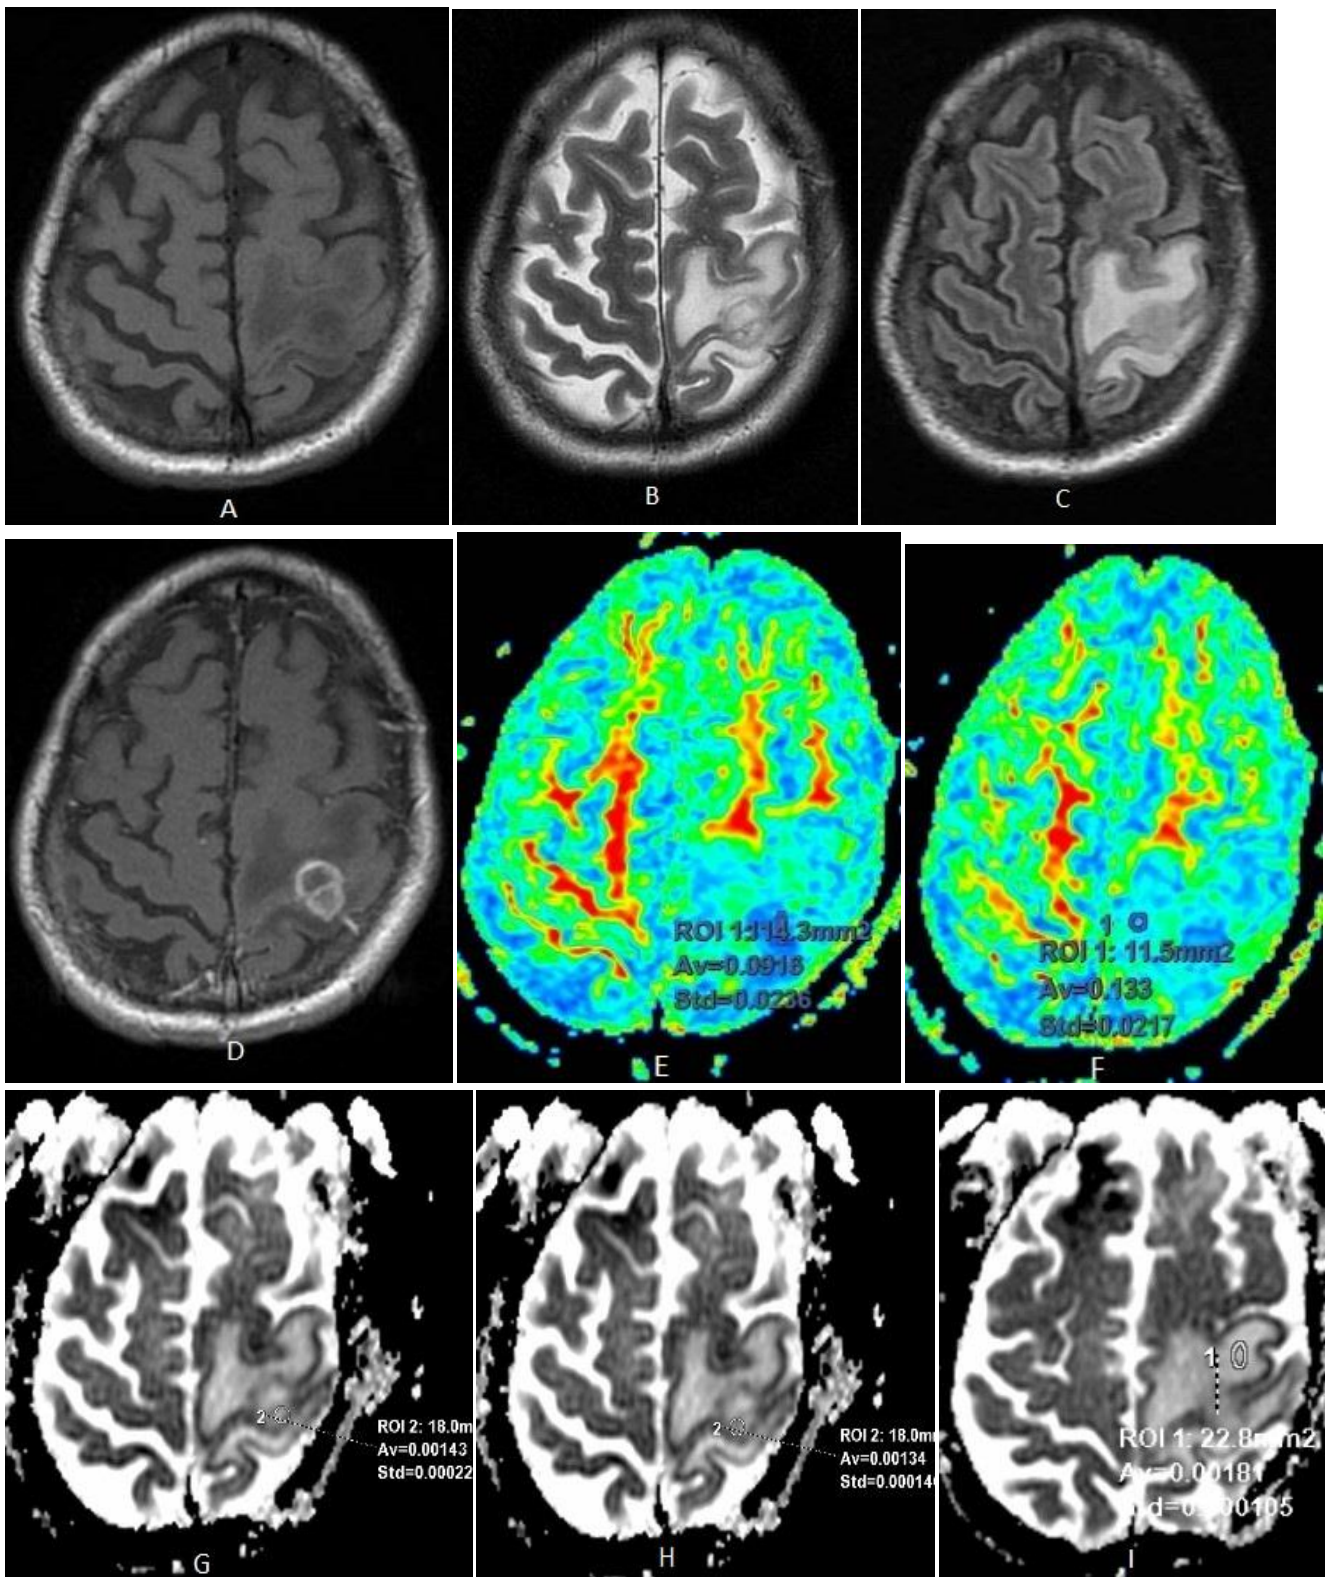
Male patient 54 years old, pathologically proved metastatic pulmonary squamous cell carcinoma (A), (B) and (C) images Axial T1, T2 and FLAIR images respectively, showing left parietal lesion with surrounding vasogenic edema and heterogeneous post contrast enhancement (D). (E) and (F) FA map with two regions of interest measured within the enhancing part of the tumor and within the immediate peri-tumoral edema demonstrate elevated FA value in the immediate peri-tumoral edema, (G) and (H) ADC map with two regions of interest measured within the enhancing part of the tumor and (I) within the immediate peri-tumoral edema
